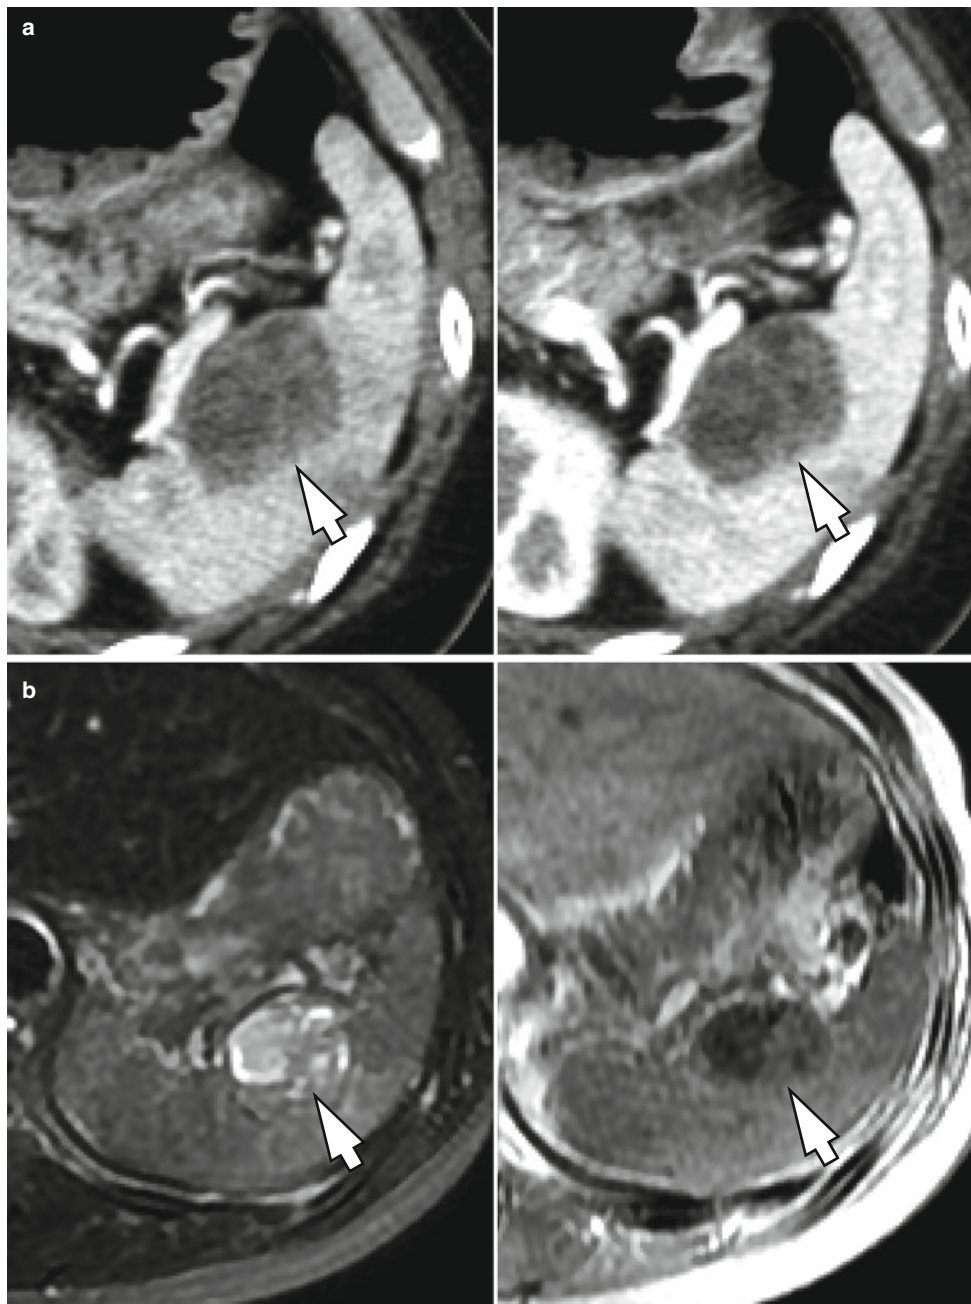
Splenic metastasis of endometrial adenocarcinoma in a 59-year-old female. (a) Arterial (*left*) and portal (*right*) phase transverse CT images demonstrate a 3 cm heterogeneously and poorly enhancing mass (*arrows*) in the spleen. (b) The lesion (*arrows*) shows heterogeneous high signal intensity on T2-weighted transverse MRI
